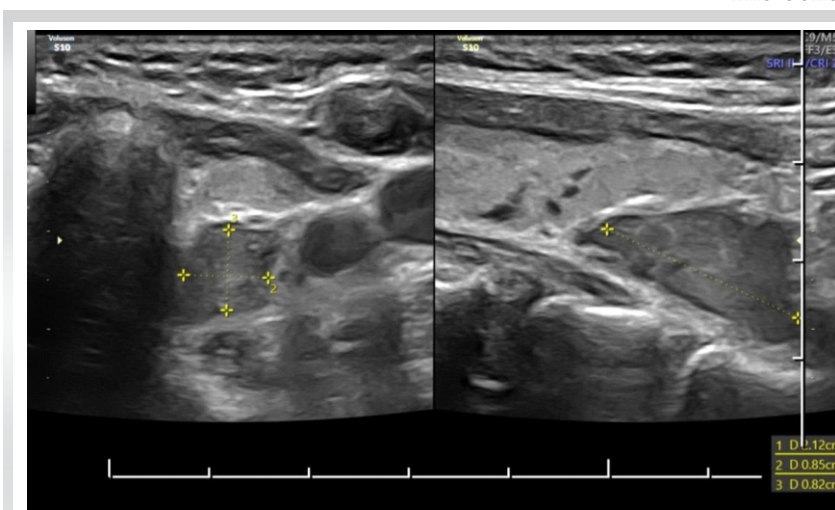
Ultrasonography of neck showing presence of parathyroid adenoma.
